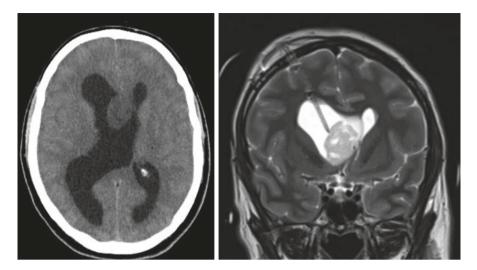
Lateral ventricle subependymoma: A CT scan showing a right ventricular tumor in a 34-year-old presenting with acute hydrocephalus. An EVD was placed, followed by an MRI (coronal T2). The tumor was endoscopically resected, avoiding the need for permanent CSF diversion. Pathology was subependymoma
